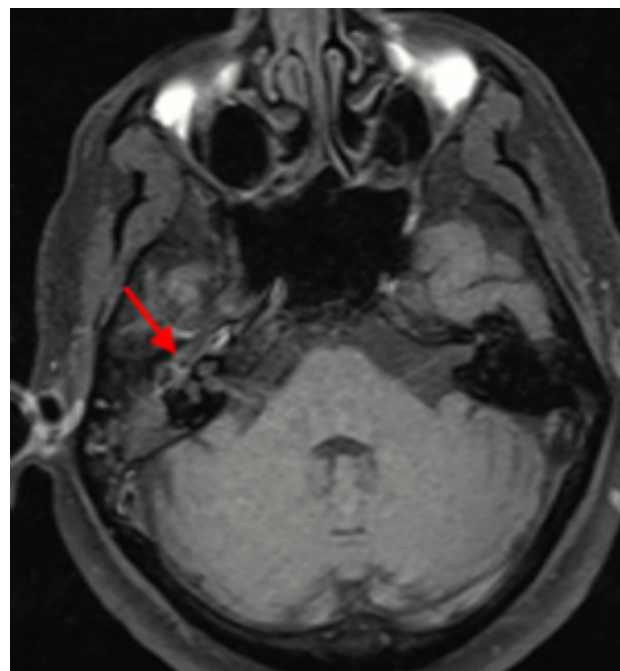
Temporal MRI demonstrated a heterogeneously enhancing lesion in the right middle ear and mastoid region. The lesion appeared to involve the facial nerve pathway at the mastoid segment.
